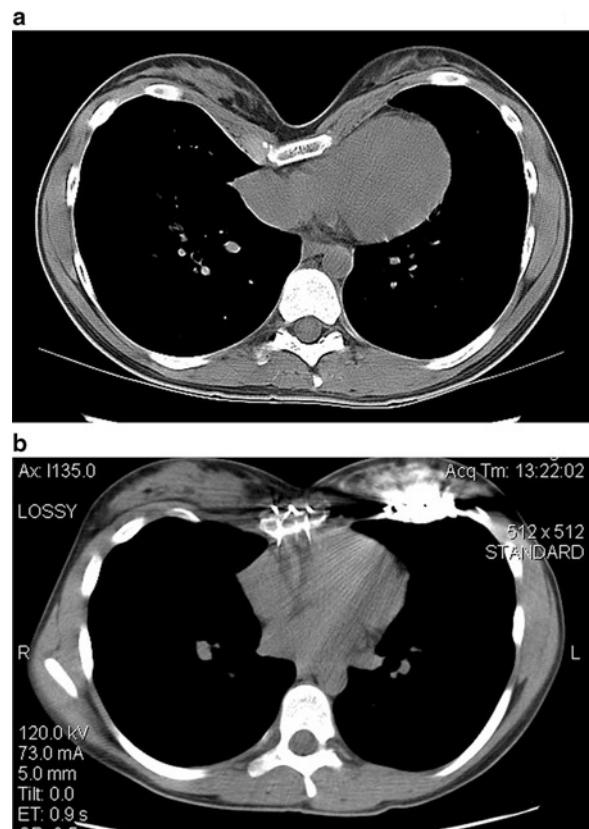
Transverse CT scans of a patient with pectus excavatum. (a) Preoperative. The sternum is compressing the right ventricle. (b) Postoperative. Internal fixation of the sternum and a portion of the pectus bar attached to the ribs of the left chest can be seen.
